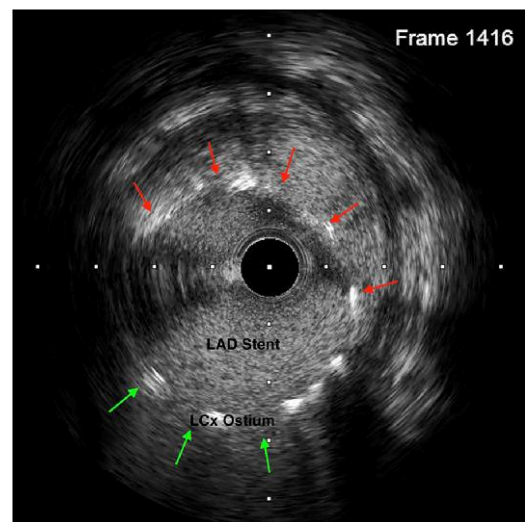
Intravascular ultrasound of malapposed proximal left anterior descending artery (LAD) stent at the distal end of the left main stem coronary artery (downward arrows) with involvement of the ostium of the left circumflex (LCx) coronary artery (upward arrows).
